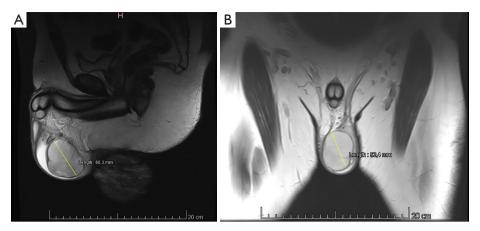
Magnetic resonance imaging showing tumor and its largest dimension in sagittal (A) and coronal (B) cuts (T2 sequence).
